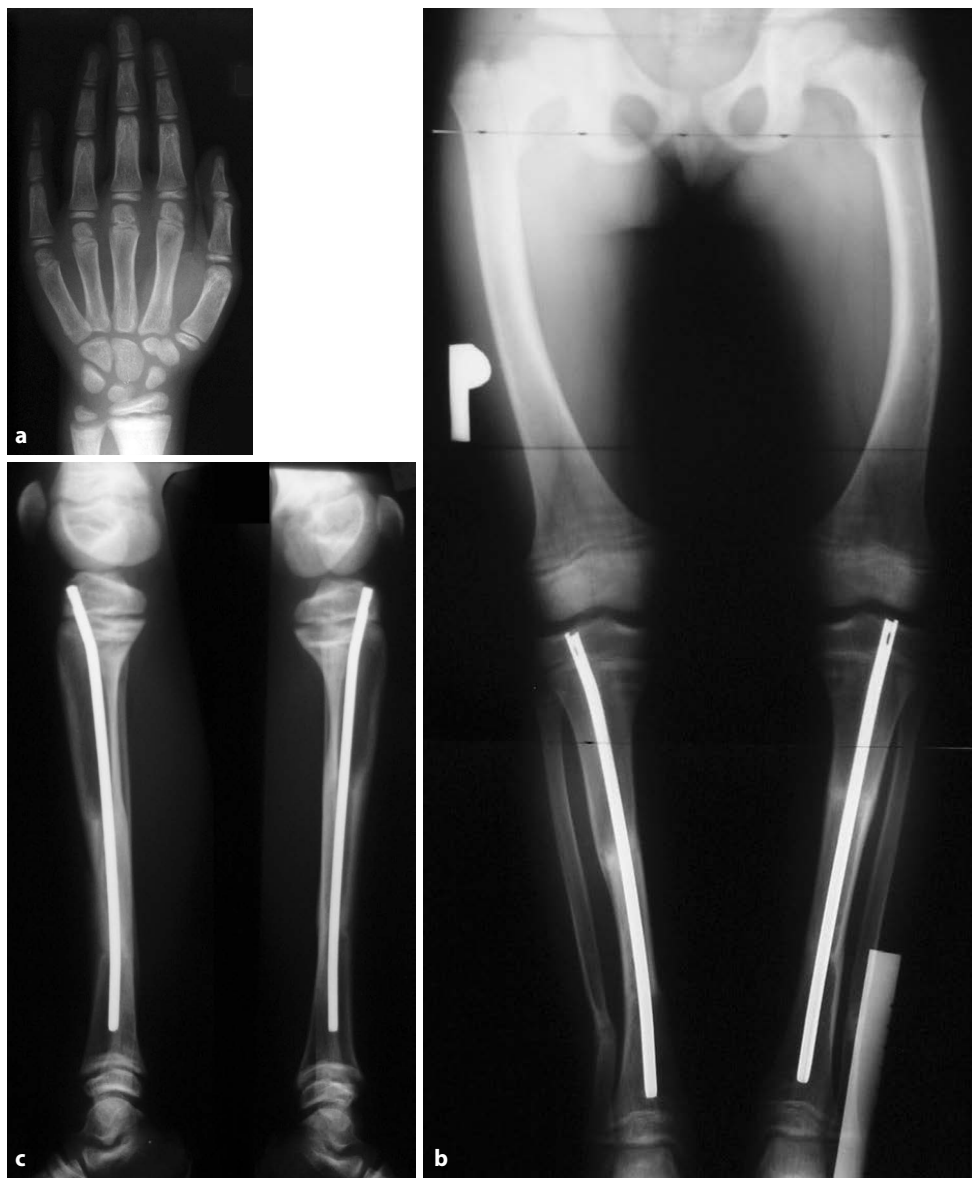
At 8 years of age, corrective osteotomy of both tibias was performed for anterolateral curvature and varus in the distal third of both tibias: a. mild rachitic changes on left hand radiograph, bone age is delayed; b, c. teleröntgenogram of the lower extremities in AP projection in standing and lateral projection images of both tibias 5 months after surgery show very good remodeling of the two-level osteotomy of both tibias (fixed with Küntscher nails) and the fibula in the distal quarter; mild rachitic changes are present in all images; d, e. (next page) Anterior and posterior photographs of the lower limbs in standing position document, in agreement with the standing radiograph – see b, shortening of the right lower limb by 1 cm and varus of the left knee joint predominantly in the supracondylar region of the left femur.
